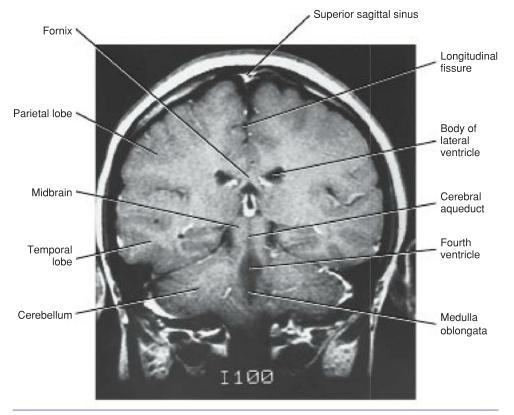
A coronal MRI (contrast enhanced) through the hindbrain showing the fourth ventricle and the surrounding neural and bony structures.
